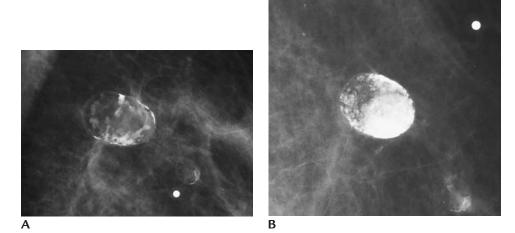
Oil cysts. (A) Two adjacent masses with mural, dense calcifications. Metallic BB used to indicate palpable finding. The benign diagnosis is established mammographically and ultrasound is not indicated. (B) A year later, the larger of the two masses has decreased in size and calcification has progressed. Metallic BB used to indicate palpable finding.
